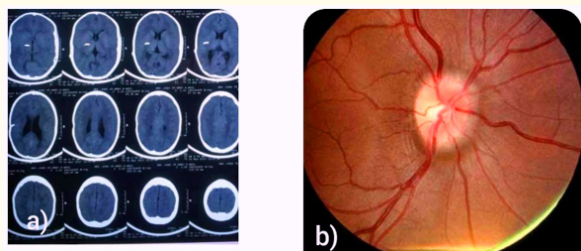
a) CT head revealed no ventriculomegaly with nearly normal looking ventricles with VP shunt in situ.
